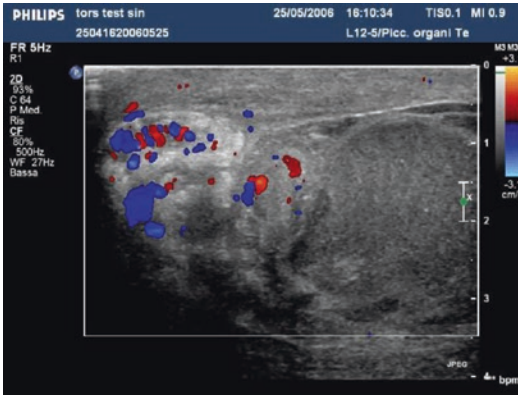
Testicular torsion: color Doppler demonstrates complete absence of intratesticular perfusion and increased para-testicular flow from collateralization of extratesticular vessels (epididymal and funicular vessels). At the upper aspect of the testis, the torted spermatic cord appears as a thickened, edematous, and ill-defined mass
